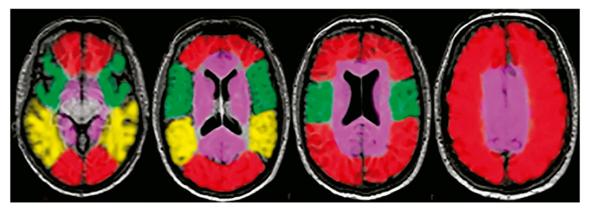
Series of axial MR images with a color overlay represents the venous drainage territories. The cortical veins and superior sagittal sinus (red), middle cerebral veins and cavernous sinus (green), transverse sinus and Labbé vein (yellow), and deep cerebral veins (lilac) are shown. Hemorrhage or edema in these territories may be indicative of CVT of the corresponding dural sinus or vein⁷⁹.
